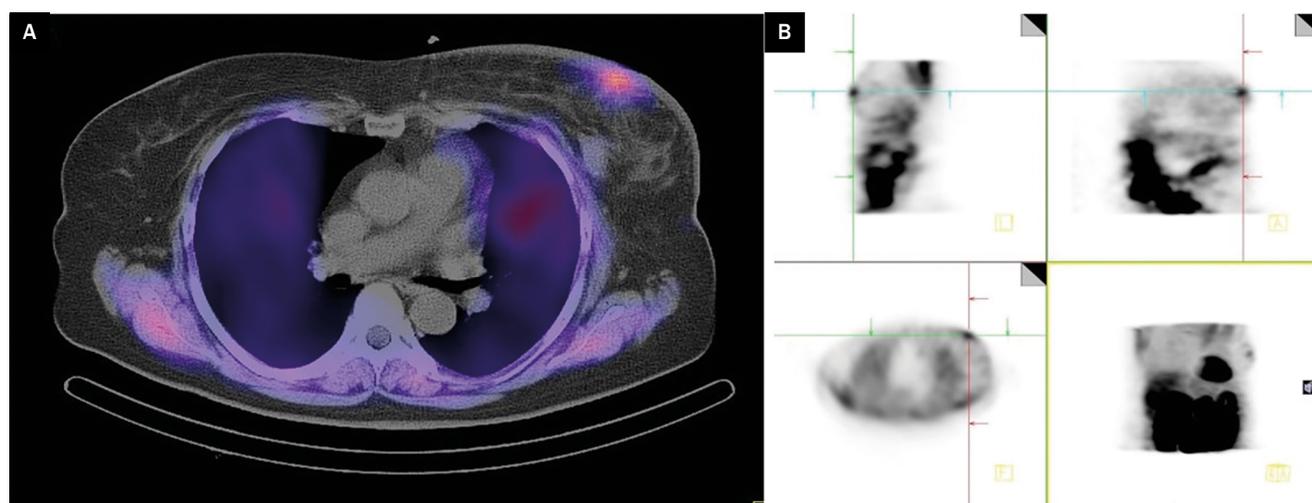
[^{99m}Tc]Tc-MIBI SPECT/CT transverse cross-section at the level of ascending aorta (A); [^{99m}Tc]Tc-MIBI SPECT whole-body maximum intensity projection images (B)
